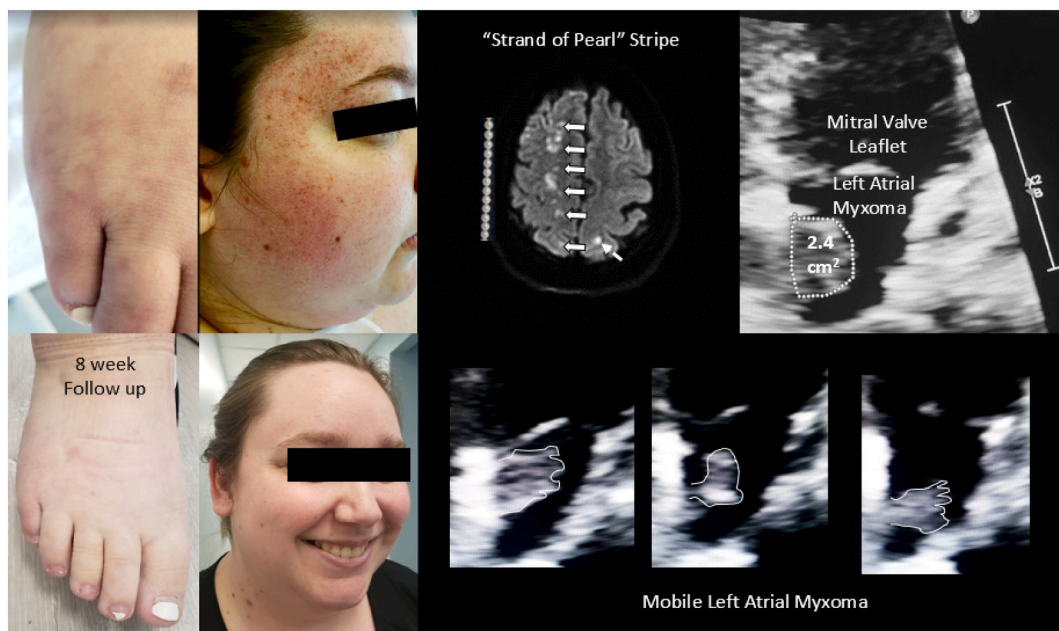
Neurocutaneous presentation of atrial myxoma and sentinel rash. A 28 y woman with preceding rash (Top row, left) presented acutely with right facial rash (Top row) and ischemic stroke (Top row, MRI DWI sequence). Enclosed arrows show the ‘strand of pearl’ pattern of ischemia in the right corona radiata. An additional small area of ischemia was seen in the left occipital lobe (arrow). Atrial myxoma was found on echocardiography (top row, right). The atrial mass was frond-like and mobile (see bottom row, right). At 8 week follow up, both her stroke deficits and rash had resolved (bottom row, left).
